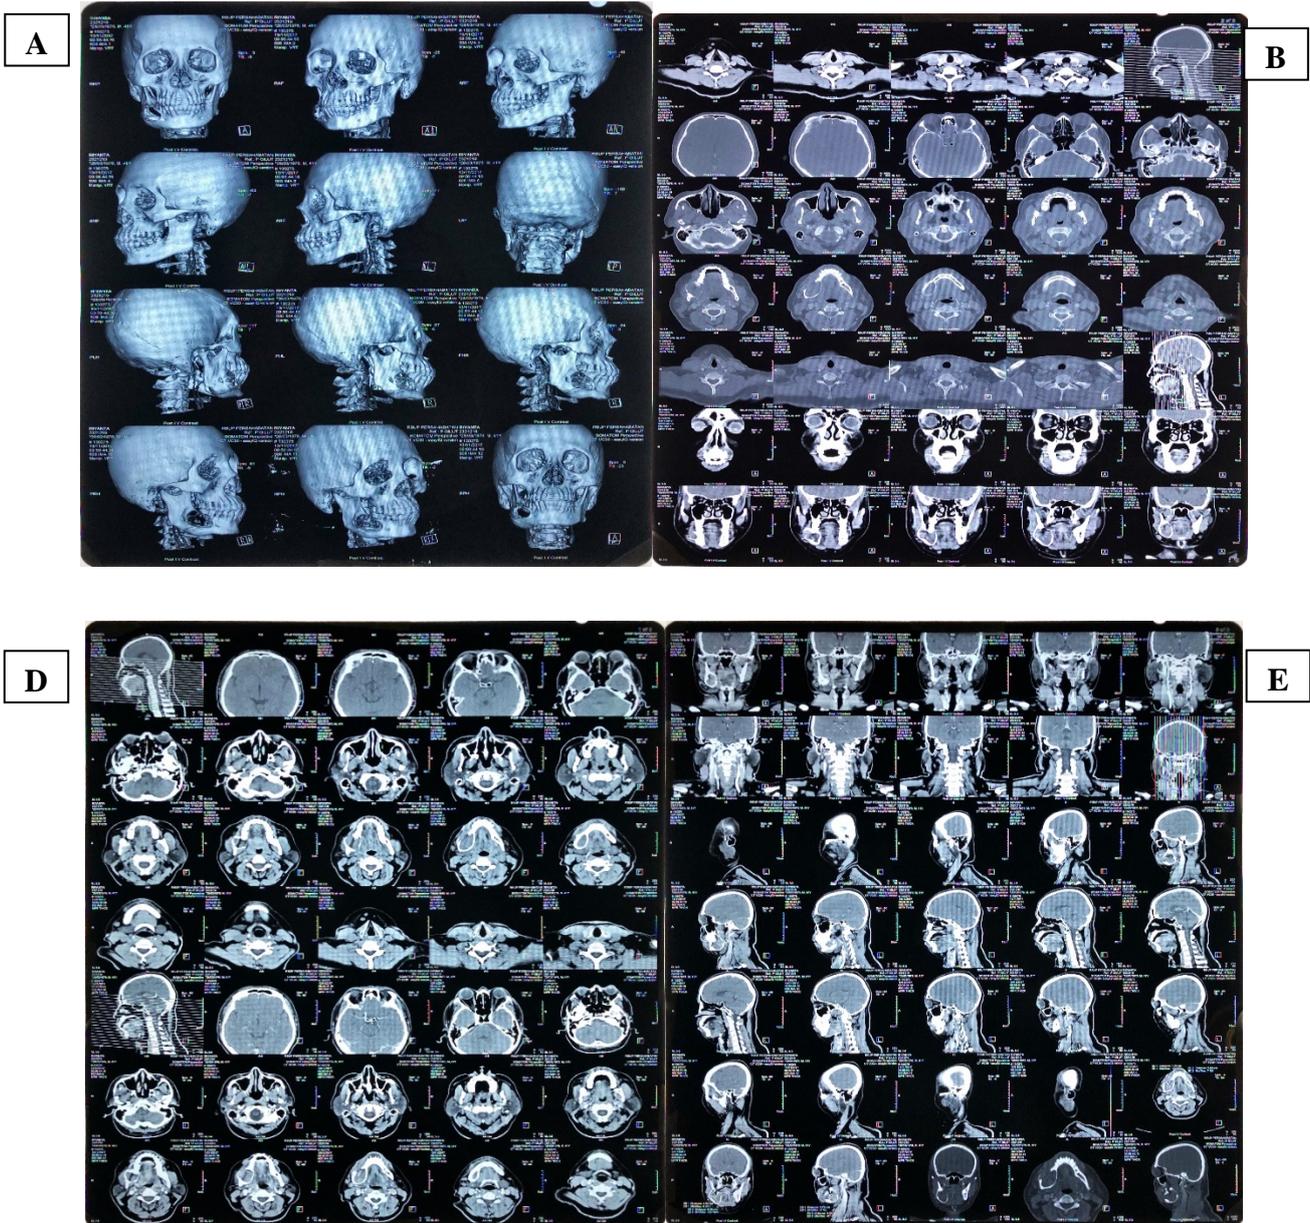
pre-operative CT Scan of case 2
